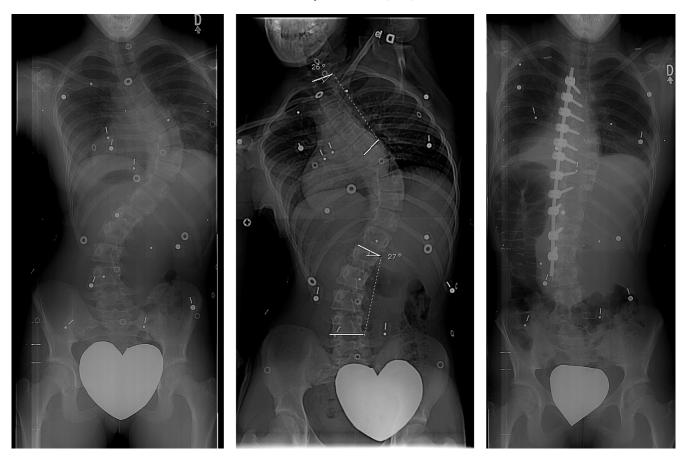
Case C: 14-year-old female with Lenke curve type 4. On bending X-rays, Cobb angles of proximal thoracic and thoracolumbar/lumbar corrected to just above 25°; those curves are therefore considered structural. Patient C was treated with fusion of the main thoracic curve from T4 to L2.
